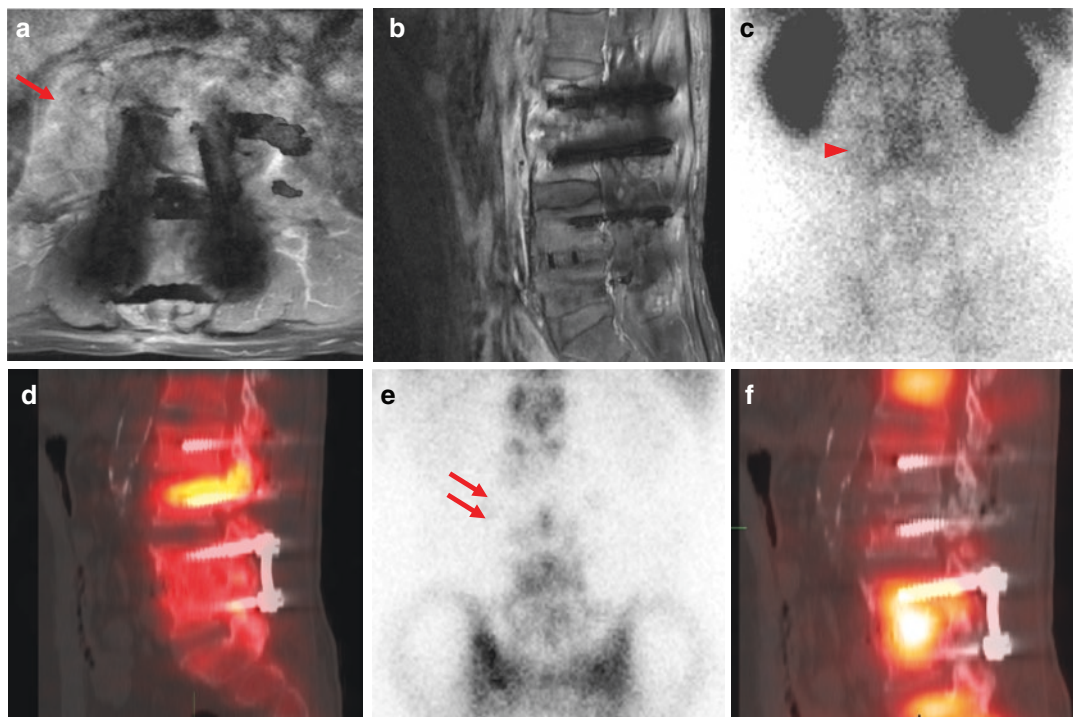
Contrast-enhanced MR images of L-spines show enhancement of paravertebral soft tissue at the level of L2–L3 (a, b). Bone scan and SPECT/CT show increased perfusion and bone uptake in the level of L2–L3
